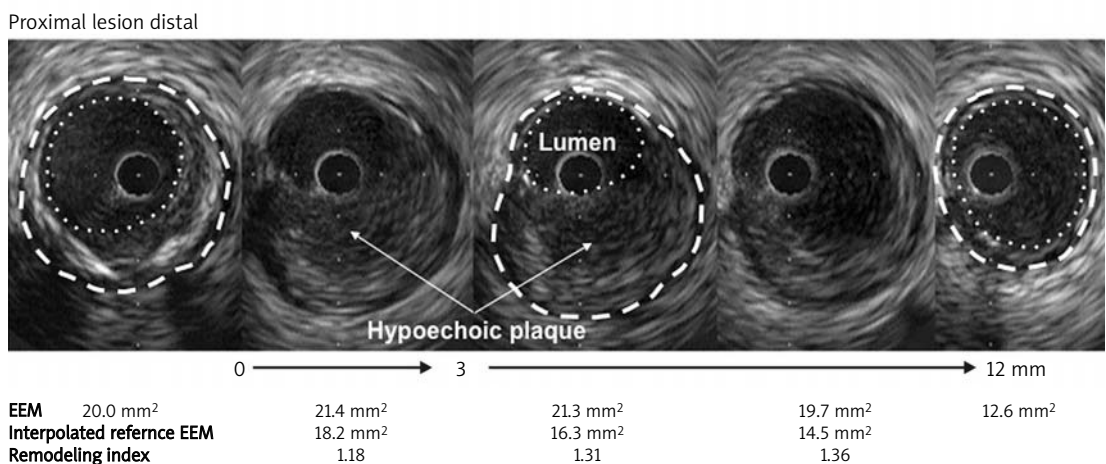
This patient presented with an acute coronary syndrome and a culprit lesion in the LAD (white arrow in the angiogram). The IVUS pullback shows the distal reference, three lesion cross-sections, and the proximal reference. The lumen is indicated by the inner dotted white line, and the EEM is indicated by the outer dashed white line, and the remodeling index is calculated as lesion EEM divided by reference EEM. Several approaches can be used to assess remodeling. The lesion EEM can be divided by the average of the proximal and distal reference EEM, an interpolated reference can be calculated (as shown), or the lesion can be compared to the proximal reference. Regardless of the approach, this patient has positive remodeling. Despite only modest lumen compromise, there is a large plaque burden (75%) at the lesion site. A large plaque burden should not be misinterpreted as representing a significant stenosis because the EEM grows to accommodate plaque accumulation and preserve lumen dimensions; in this example, the area stenosis (equivalent to the angiographic diameter stenosis) only measured 39%. In addition, there is a large area of superficial, eccentric, hypoechoic plaque (plaque that is less dense than the reference adventitia) (from Mintz GS. Intracoronary Ultrasound. London, Taylor and Francis Group, 2005)
